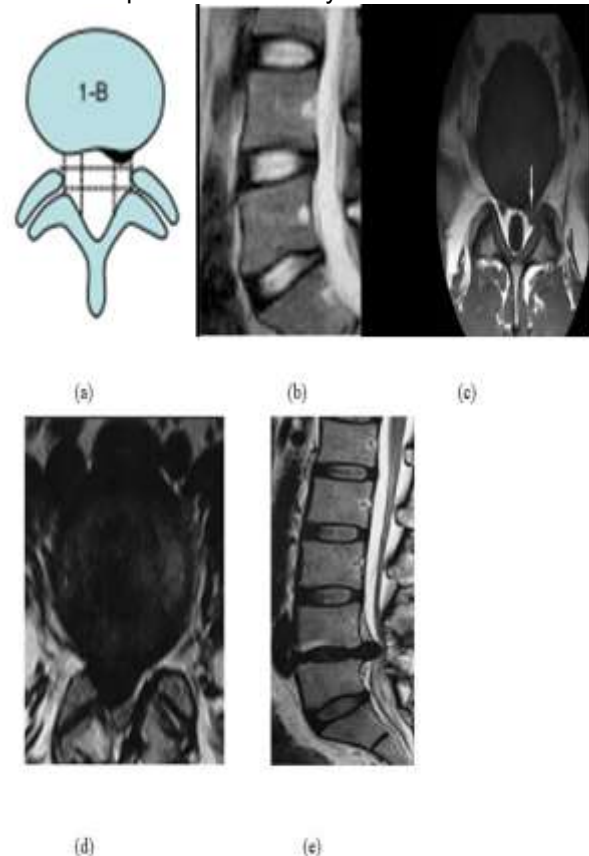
(a) Grade 1 disc herniation with minimal impact on nerve compression, (b) MRI axial T₂ weighted image and (c) sagittal T₁ shows L4-L5 lumbar disc herniation. (d) MRI axial T₂ weighted image and (e) sagittal T₁ shows L4-L5 lumbar disc herniation.
